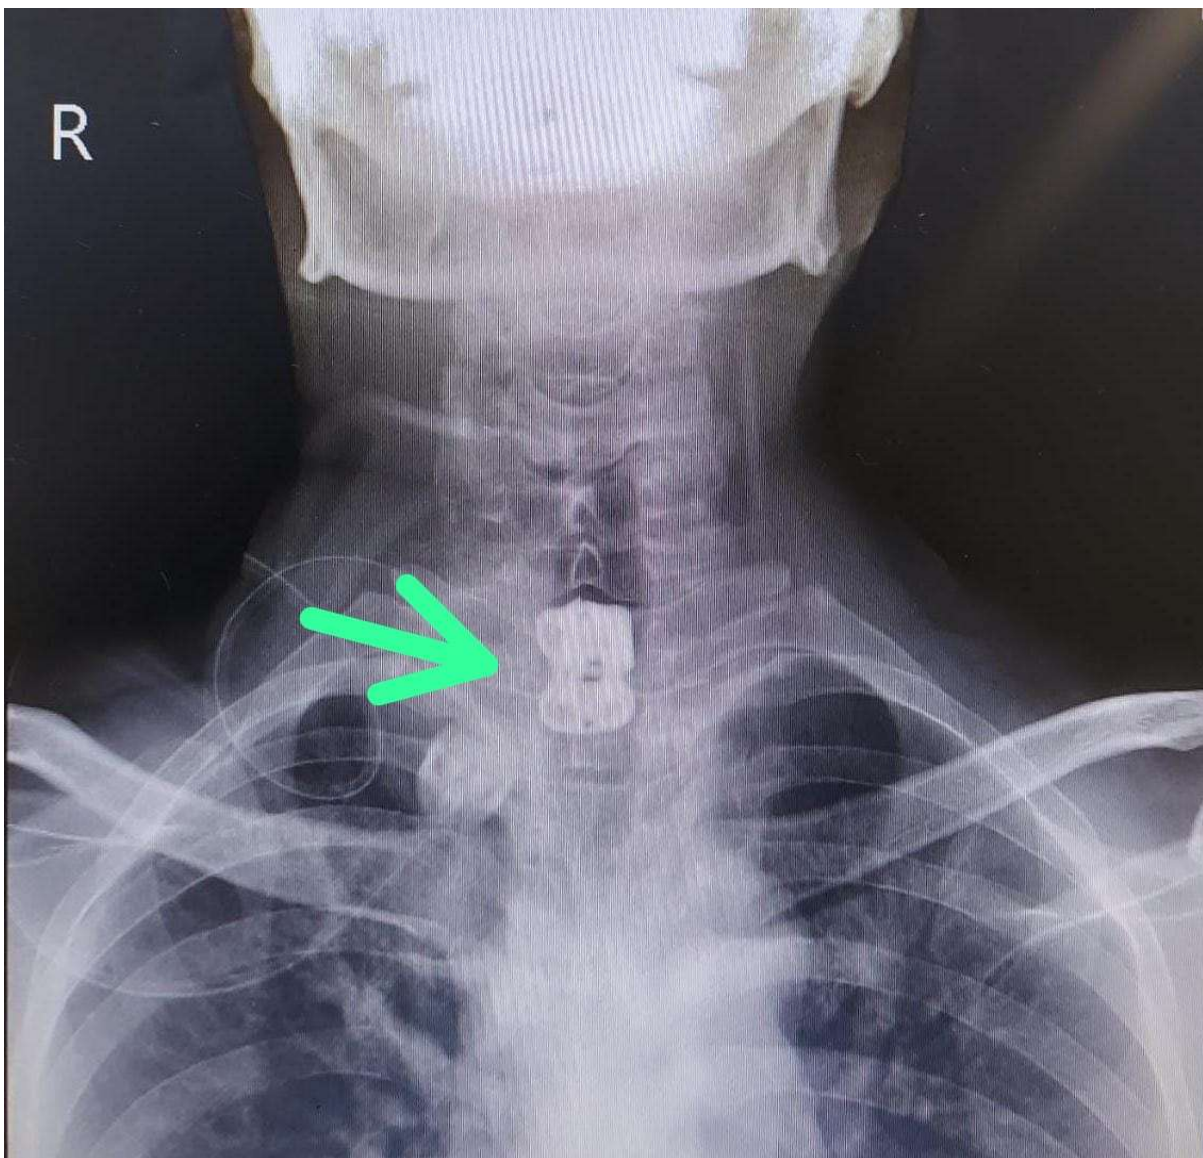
X-ray cervical spines AP view (Green Arrow) showing metallic plate and screw in situ
